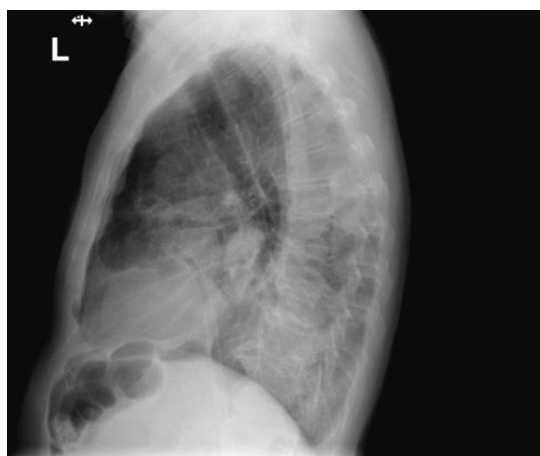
Lateral chest X-ray: left pleural thickening, mediastinal shift, and left lower lobe hypoventilation
